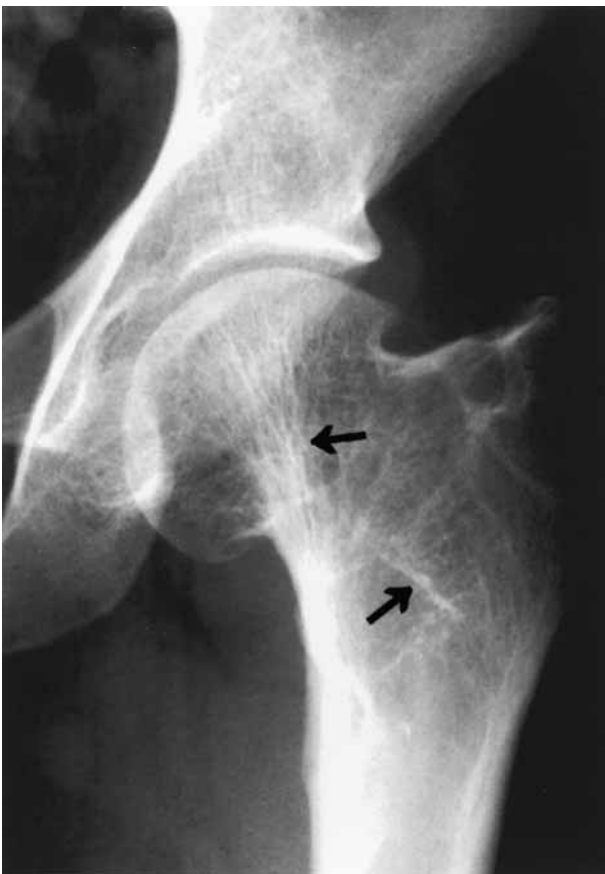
Radiograph of hip (AP view) showing complete incorporation of the fibula, 17 years after fibular grafting. Note the revascularised femoral head and the (healed) subtrochanteric fracture which occurred 12 years post surgery.
